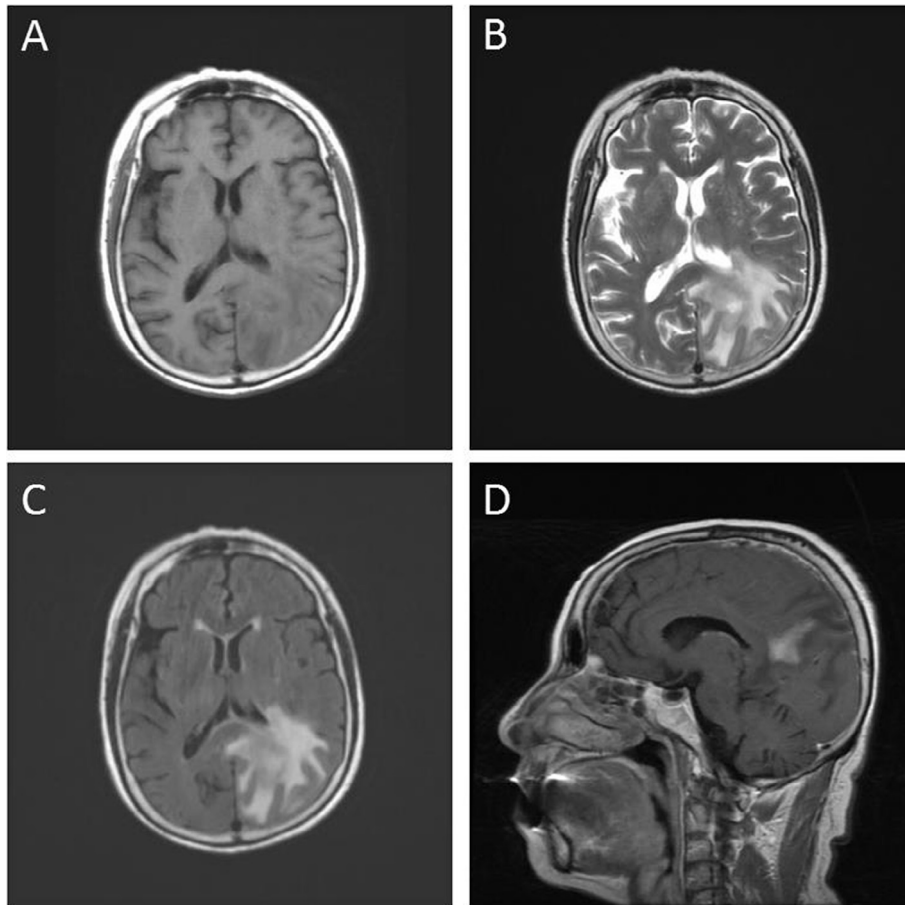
Case 1: MRI of primary central nervous system lymphoma A: Slightly hypointensity on T1WI, B: Hyperintensity on T2WI, C: Hyperintensity on T2-FLAIR, D: with enhanced scanning, the lesion became more uneven with edge of “sharp angle sign” and “villous edema” of slightly prolonged T1 and prolonged T2 appearing around the lesion.
